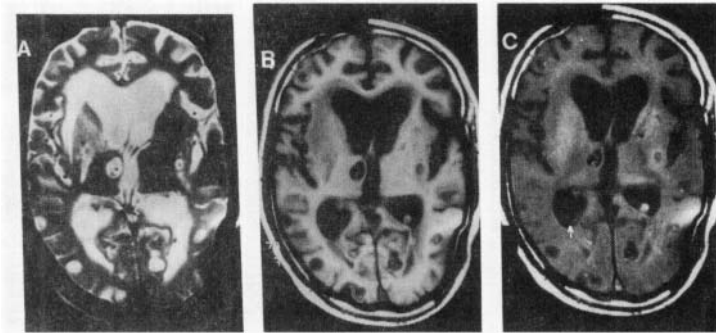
Cisternal cysticercosis. T2-weighted axial image (a) at the level of third ventricle shows dilated Sylvian fissures bilaterally with evidence of hydrocephalus. T1-weighted axial image (b) shows evidence of septae in the right Sylvian fissure and a well-defined cyst with scolex (arrow) in the left Sylvian fissure. Postcontrast T1-weighted image (c) shows enhancement along right Sylvian fissure (arrow) suggestive of meningitis
